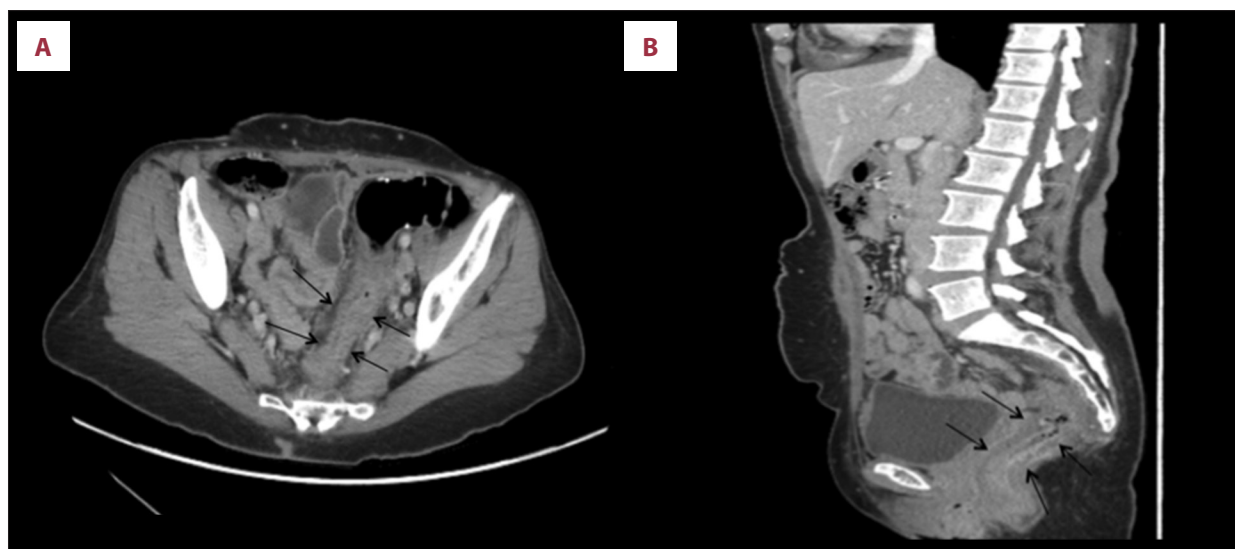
CT scan showed rectum is slightly collapsed with interval decrease of the rectal wall diffuse mural thickening suggestive of infectious/inflammatory changes. (A) Axial view and (B) sagittal view.
